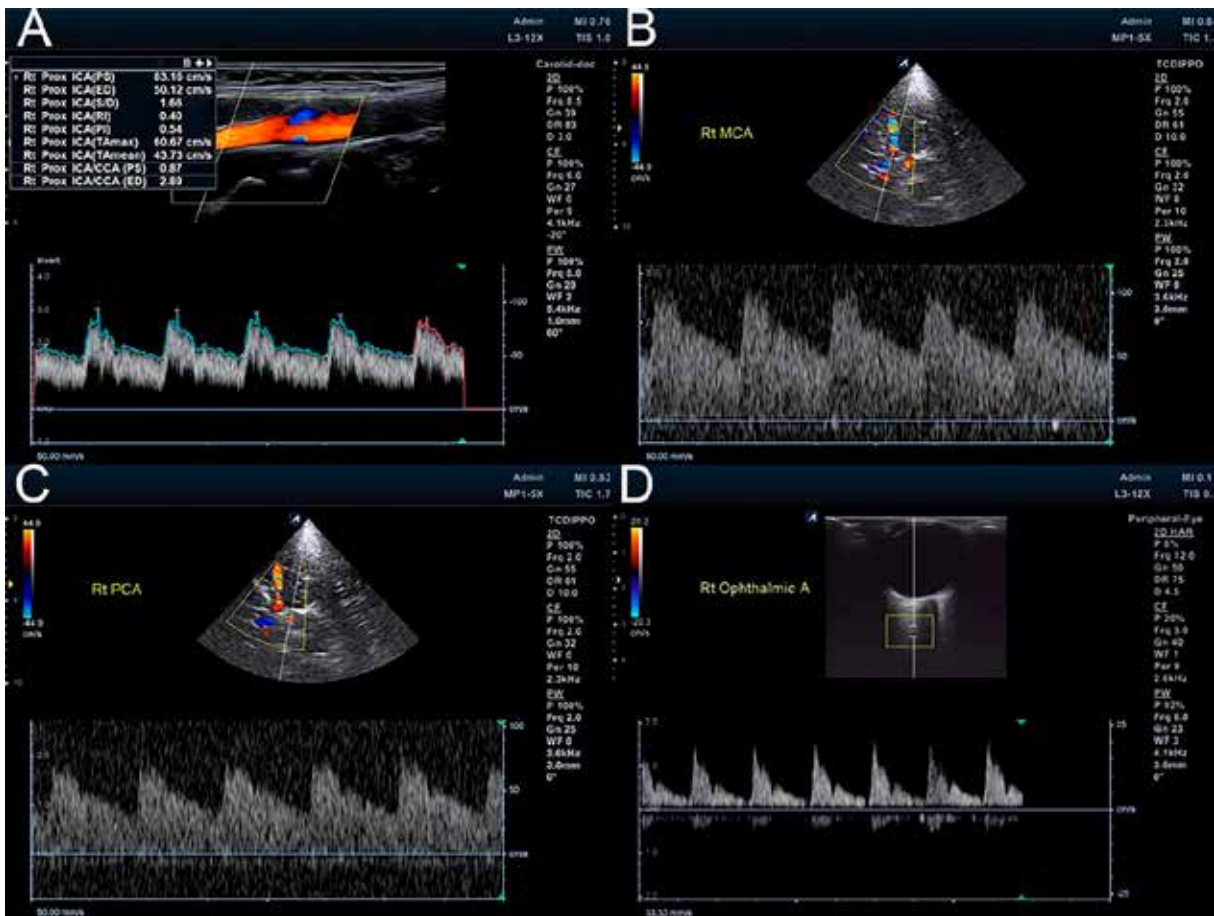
Color-coded doppler ultrasound of the carotid three weeks after the initial diagnosis. A. Normalisation of flow parameters in the right internal carotid artery. B. Right MCA showing a slightly increased maximal systolic speed and PI, suggestive of a normalisation in flow parameters in right MCA and its distal arterial network. C. Normalisation of the initial increased maximal systolic speed of the right PCA, suggestive of normal flow in the collateral leptomeningeal arteries. D. Anterograde flow in the right ophthalmic artery showing a normal flow profile suggestive of a deactivation of collateral arterial supply of the intracranial ICA.
